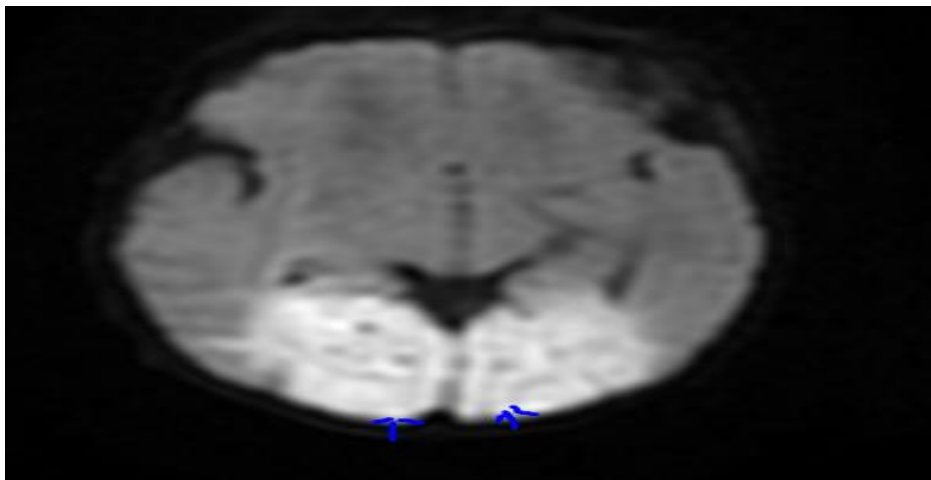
Axial Diffusion Weighted Image of Brain MRI: Bilateral occipital cortex involvement in a term neonate with Hypoglycaemic Brain Injury.
